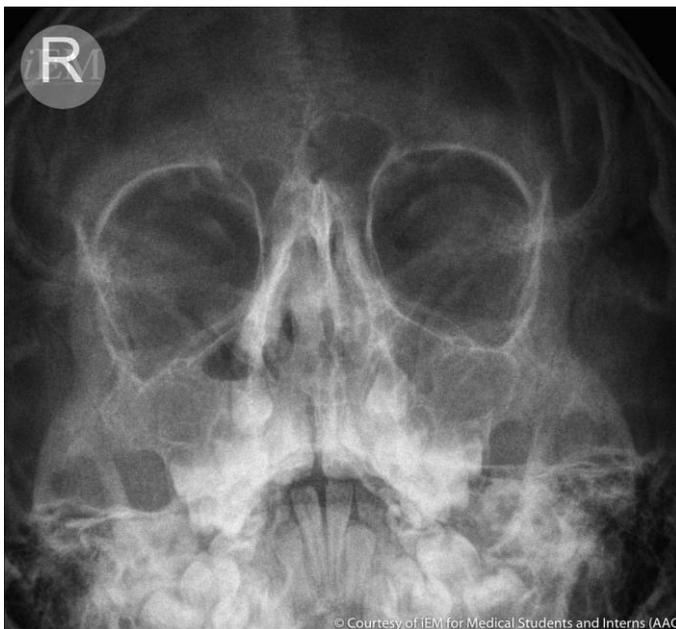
X-ray - acute sinusitis. Air-fluid level in the right maxillary sinus and loss of air in the left maxillary sinus. Air presence is also decreased in ethmoidal sinuses. (by iem-student.org is licensed under CC BY-NC-SA 2.0, not modified)
